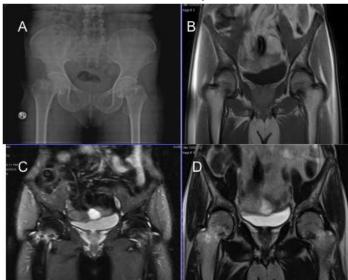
(A)-Plain Radiograph Shows Mild Osteoarthritic Changes In Both Hip Joints.(B-D) Coronal Mri Images Show Linear Hypointensity (On All Sequences) Along Bilateral Femoral Necks With Surrounding Marrow Edema. Final Diagnosis- Stress Fractures Of Both Femoral Necks.
